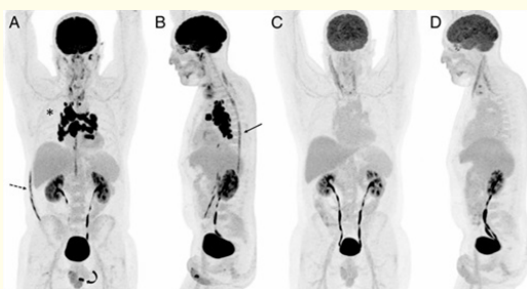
<sup>18</sup>F-FDG PET/MRI for Diagnosis and Treatment Efficacy Evaluation of Spinal Sarcoidosis [8].
